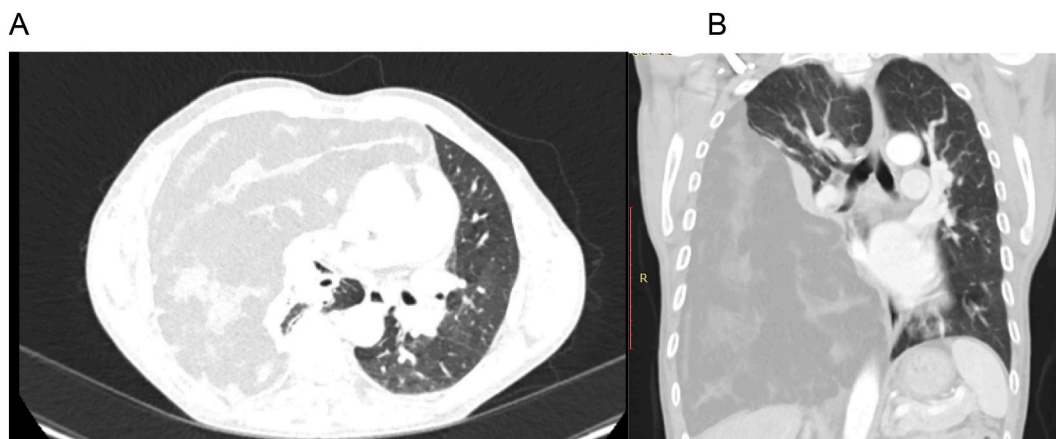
Contrast chest CT showing large fat attenuating mass filling the right pleural cavity with significant mediastinal shift: A- axial view and B- coronal view.
